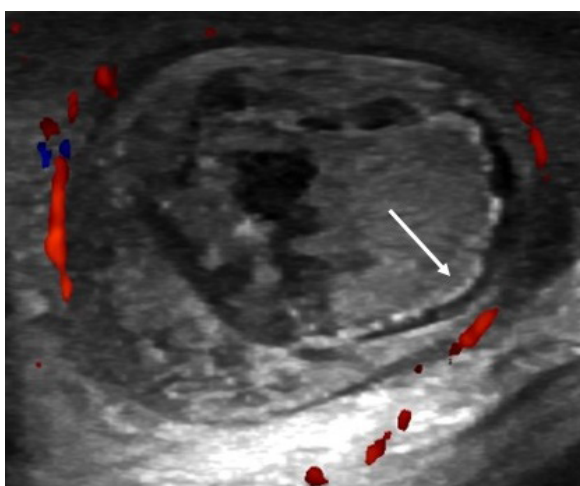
Sonographic image of the right testicle demonstrating edema and heterogeneous texture of the parenchyma with peripheral hyperechogenic foci (calcifications – arrow) and absence of vascular flow.
